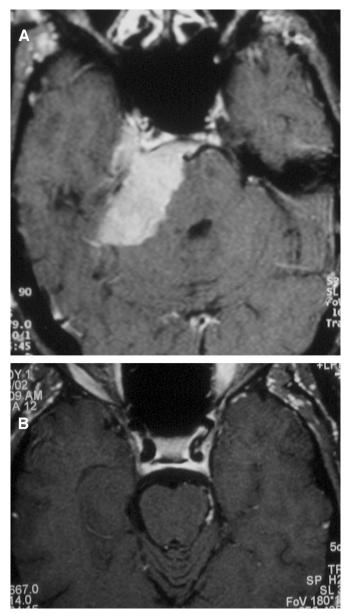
A, Axial T1-weighted gadolinium-enhanced brain magnetic resonance imaging in a patient with an isolated, acute-onset, right fourth nerve palsy. A large enhancing mass consistent with a meningioma is seen. B, Axial T1-weighted gadolinium-enhanced brain magnetic resonance imaging in a patient with an isolated, acute-onset, left fourth nerve palsy. A small enhancing lesion of the fourth nerve fascicle consistent with a schwannoma is identified.
